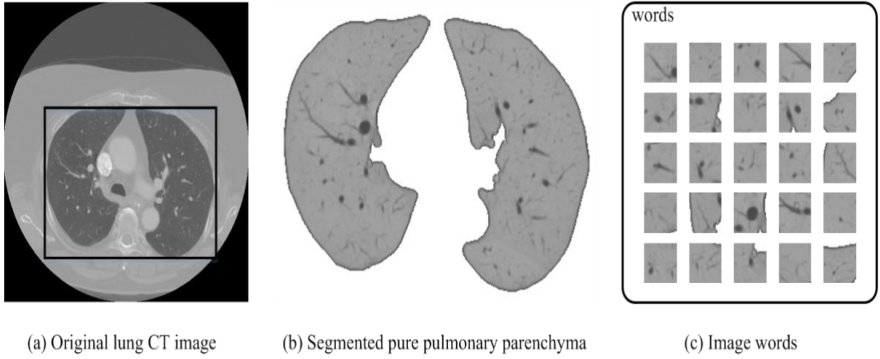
Lung CT images processing performance: from original images to image words.
